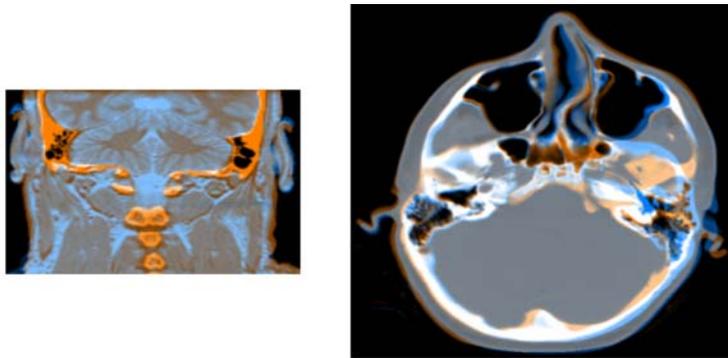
Superimposing registered data (NMR/CT, CT/CT)
